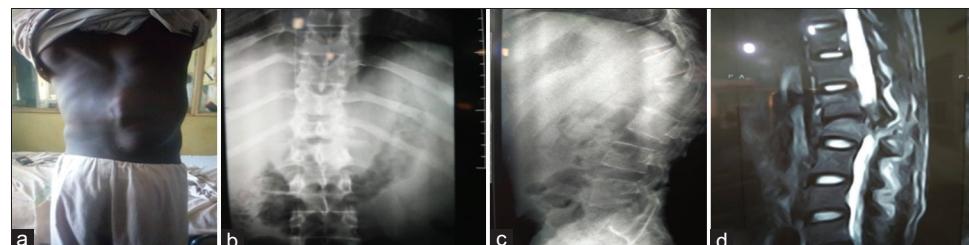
Radiology images of the tuberculosis spine in (a) a 20-year-old man with tuberculosis kyphosis in the thoracolumbar spine and paraspinal cold abscess extending to the right lumbar triangle and paraparesis (b and c) Plain radiography showing wedge collapse of L2 and kyphosis, (d) T2-weighted magnetic resonance imaging scan showing compression of the thecal sac, collapse of L2, degenerated disc at L1/L2 disc space and paravertebral abscess
